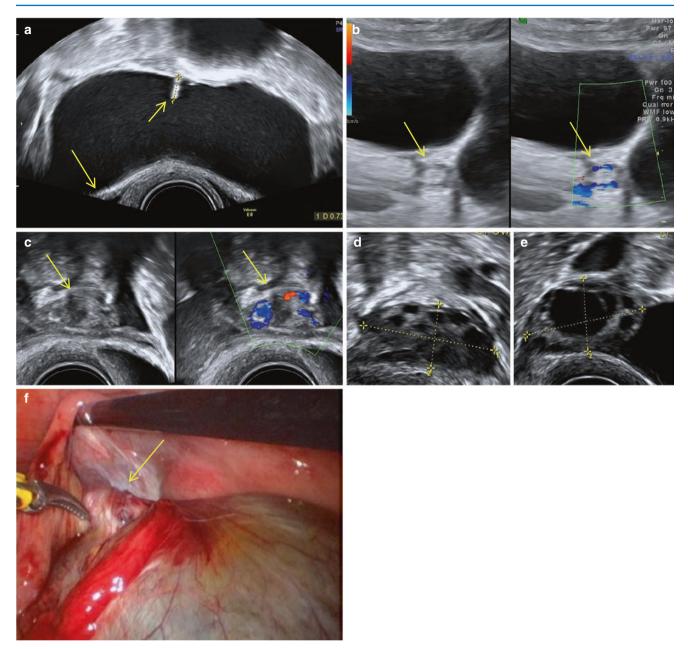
Torsion of a left hydrosalpinx. (a) Elongated cystic mass with a short, incomplete septum (*short arrow*), turbid contents and thick walls (*long arrow*), suggestive of a torsed hydrosalpinx with haemorrhage within. (b) Whirlpool sign of pedicle seen on TAS in greyscale and Doppler (*arrows*). (c) Whirlpool sign on TVS in greyscale and Doppler (*arrows*). (d, e) Normal left and right ovaries of the patient. (f) Laparoscopic image of the torsed hydrosalpinx, showing the twist (*arrow*)
